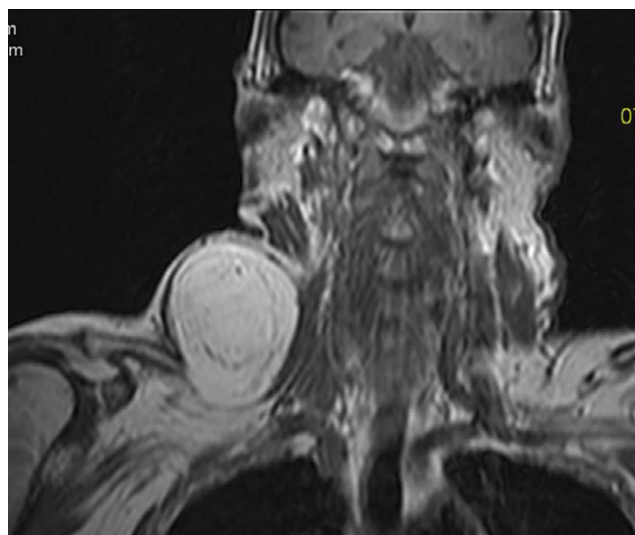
T1-weighted coronal MRI showing a large right-sided 7-cm liposarcoma. This was a long-standing benign lipoma that suddenly increased in size causing pain, with malignant transformation.
